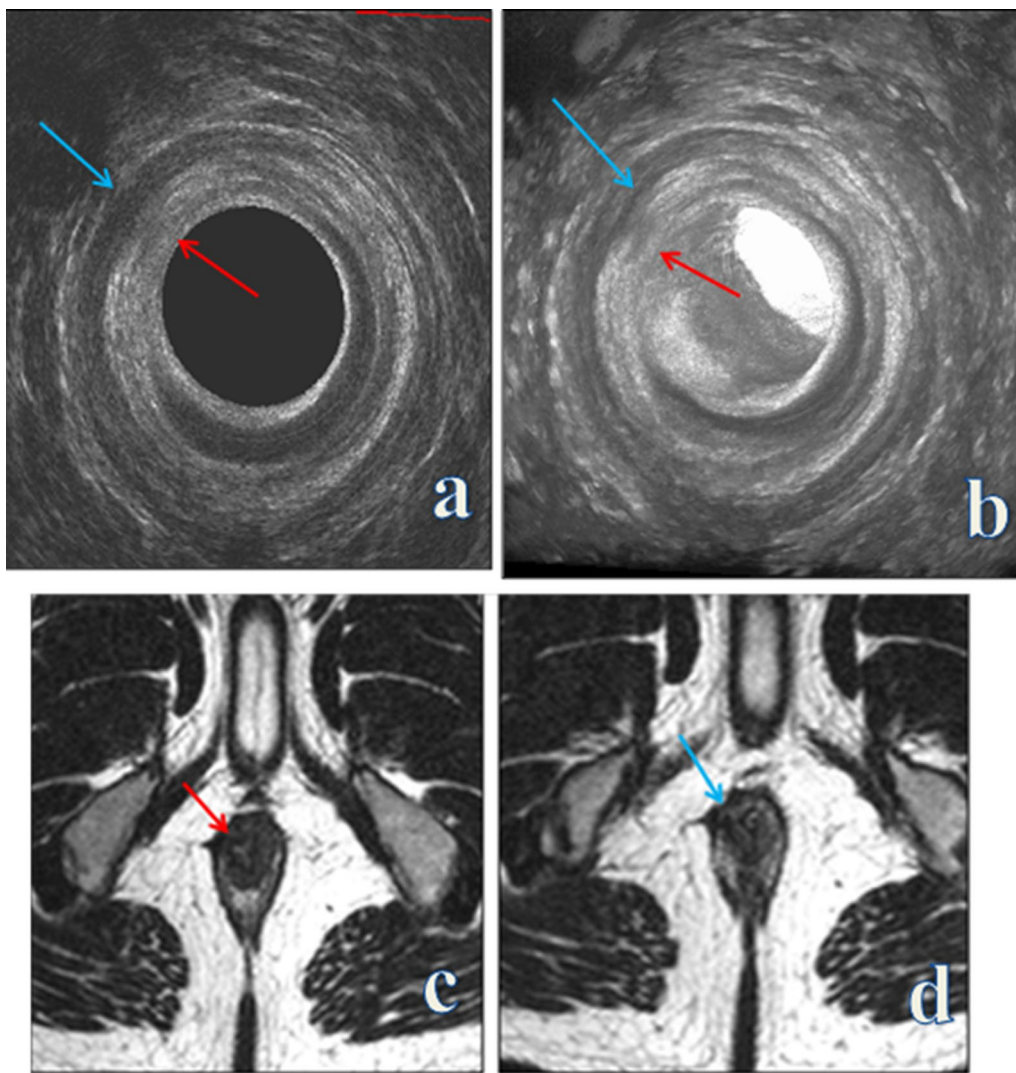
a axial and b axial render mode EAUS images show IAS defect from 8/9 to 12 O'clock (red arrows). Intact EAS (blue arrows) by EAUS. c, d Axial T2 WI MRI images show internal (red arrow) and external anal sphincters (blue arrow) right sided dark T2 signal scar tissue extending from 9 to 12 O'clock
